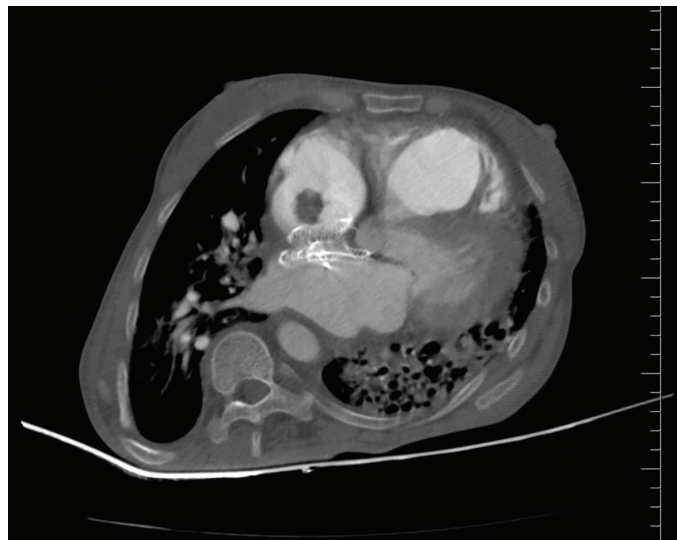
Computed tomography angiography of the thorax demonstrating the ball-like thrombus in the right atrium adjacent to the atrial septal defect closure device
